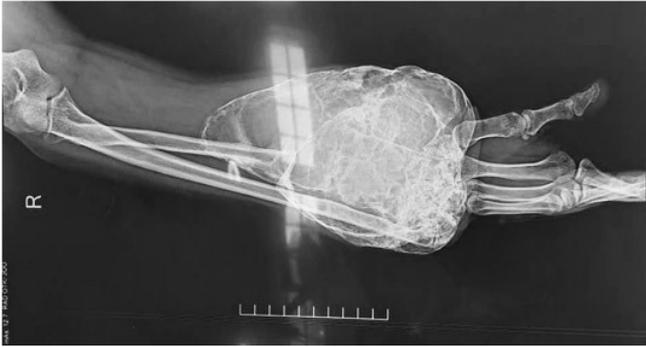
Plain radiograph of the right forearm.
